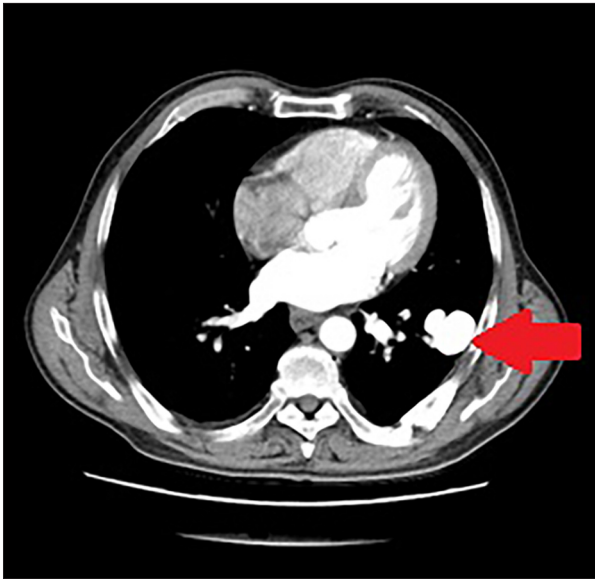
Contrast-enhanced chest computed tomography scan. The image demonstrates a well-circumscribed, enhancing nodular lesion in the left lower lobe, consistent with a pulmonary arteriovenous malformation. Prominent vascular structures contiguous with the lesion represent the feeding artery and draining vein.
